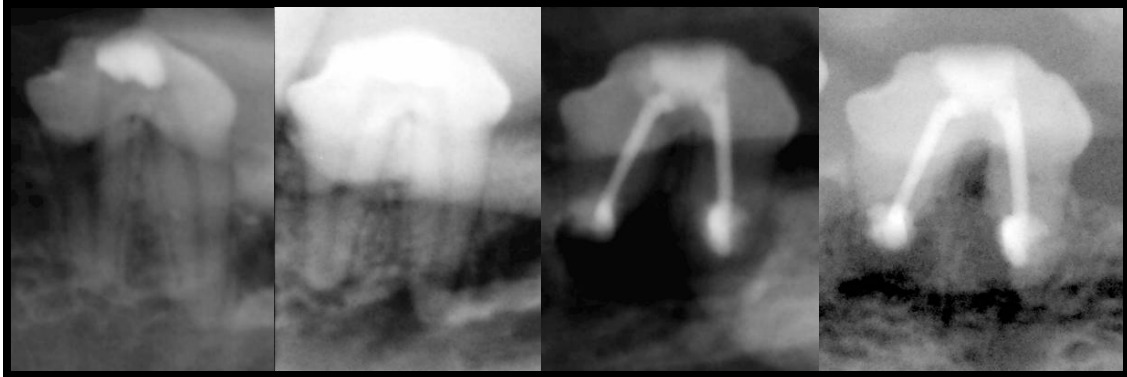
“Control tooth” radiographs post-surgical vs. 6 month follow-up
